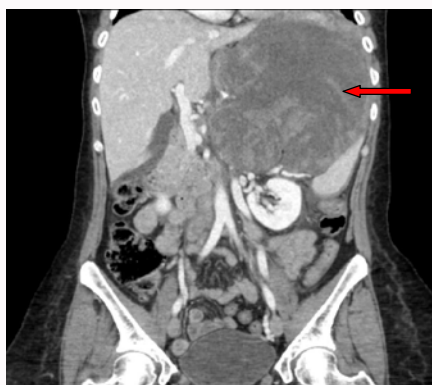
This is a coronal image of the CT abdomen and pelvis. The red arrow shows the intraabdominal mass herniating through the diaphragm into the left thoracic cavity with suspected active hemorrhage.
